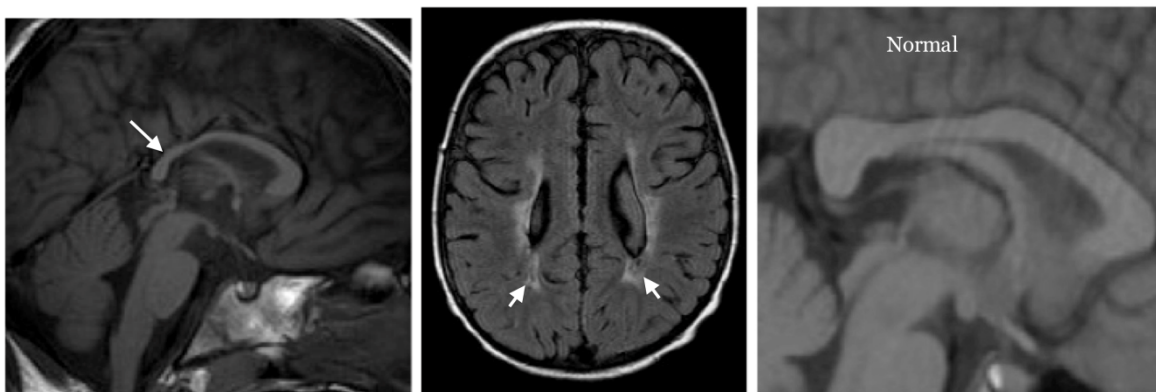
Sagittal T1 weighted image showing predominantly posterior corpus callosum thinning (long arrow) corresponding to predominantly posterior peri-ventricular leukomalacia (short arrows) on FLAIR after a perinatal hypoxic insult, with a comparison sagittal T1 weighted image showing thickness of the corpus callosum in a normal child (Normal)
